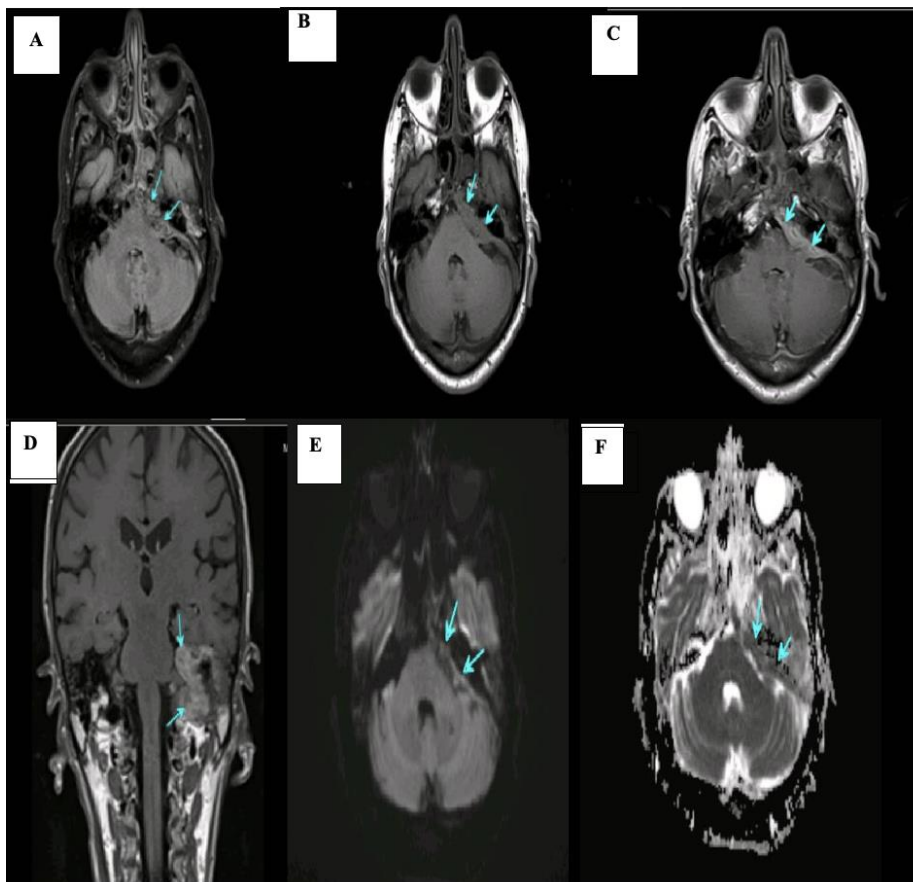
MRI findings in 48-year-old female patient presented with dizziness and headache. (A) axial T1W and (B) axial T2W show extra-axial left sided CPA tentorial isointense sheet-like lesion (arrows)(C) and (D) contrast enhanced axial and coronal cuts show post-contrast heterogenous enhancement (arrows), (E) and (F) DWI and ADC map images show relative restricted diffusion (arrows) and high ADC value ($1.69 \times 10^{-3} \text{ mm}^2/\text{s}$), pathologically proved adenoid cystic carcinoma.
